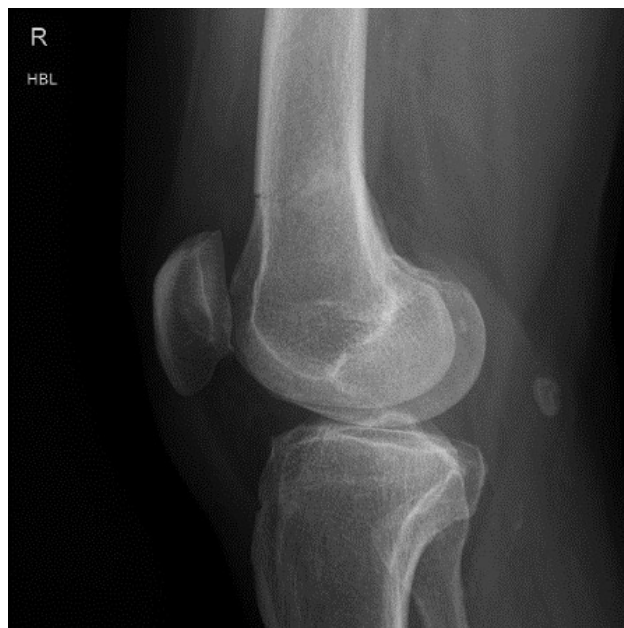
Lateral plain radiograph demonstrating transverse femoral diaphyseal stress fracture
